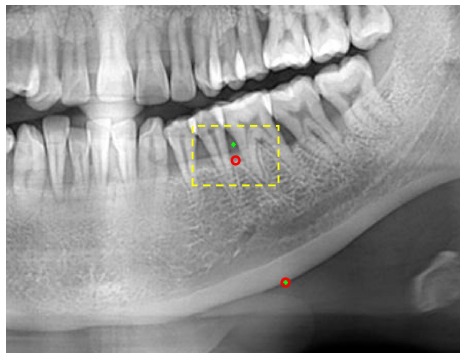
The comparison between the feature points and their labels of the test sample S22 for calculating *MRI*
